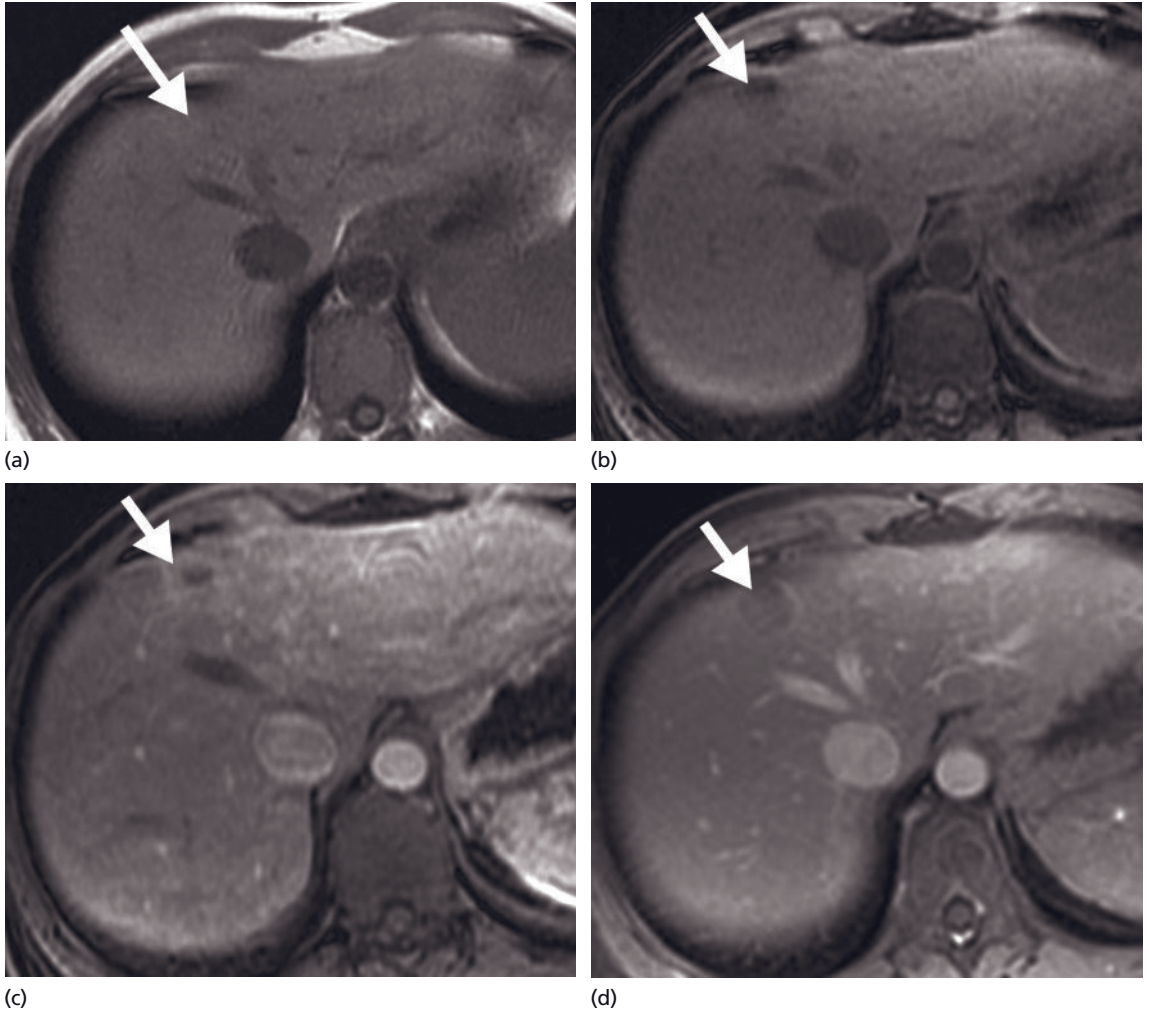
Hepatic adenoma. (a,b) Axial, T1-weighted images show a medial segment left lobe lesion that is subtly hyperintense on the in-phase sequence (a, arrow), then becomes heterogeneously hypointense on the fat-saturated sequence (b, arrow), consistent with a fat-containing mass. (c) Following
